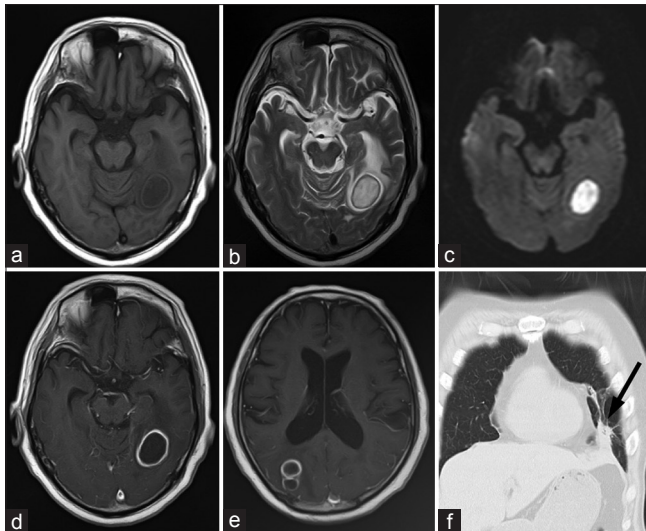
Preoperative images. (a) Hypointensity of the lesion and the isointensity of its peripheral rim are seen on axial T1-weighted imaging (T1WI). (b) Hyperintensity of the lesion and the hypointensity of its peripheral rim are seen on axial T2-weighted imaging (T2WI). (c) Hyperintense signals obtained using diffusion-weighted imaging. (d and e) Bilateral ring-enhanced lesions are seen on axial T1WI following the administration of Gd-DTPA as contrast agent. (f) A small nodule in the lingular segment of the left lung (arrow) is revealed by coronal thoracic computed tomography
